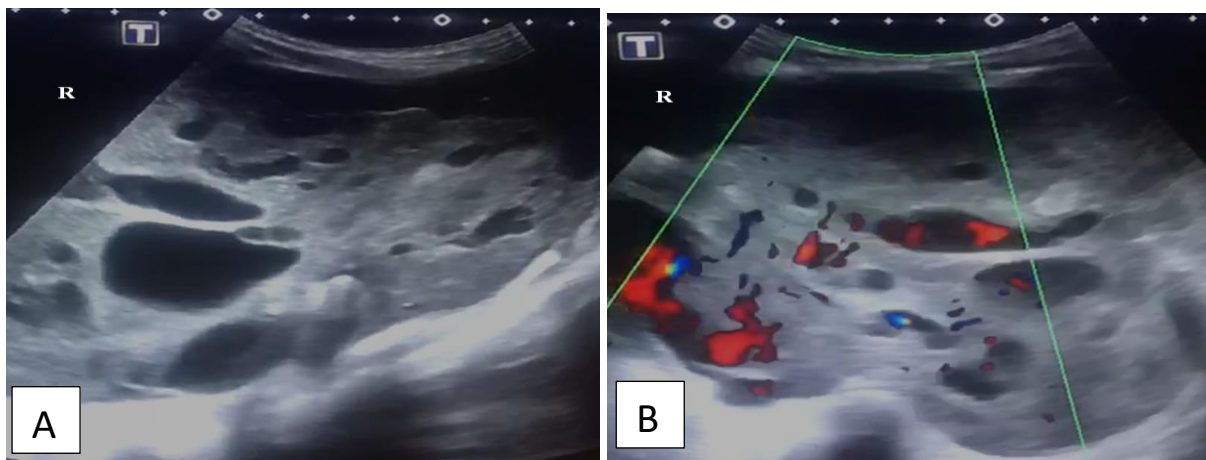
A-Chest ultrasound shows a large hypoechoic area containing multiple cystic changes in solid mass lesions. B-Chest Doppler ultrasound revealed a large hypoechoic solid lesion that is highly vascular in some areas.
